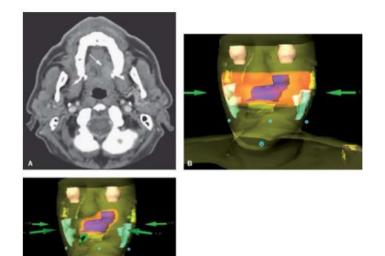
T2NO adenoid cystic cancer of the palate with major perineural invasion. Computed tomography performed before local excision (A, arrow: tumor); target includes right palatinus major nerve until base of skull. Dose distribution (25 × 2 Gy primary field) in transversal planes; conventional bilateral opposed fields (B); intensity-modulated radiation therapy (7 fields, 40 segments) (C); 95% isodose of 50 Gy in *red*.
